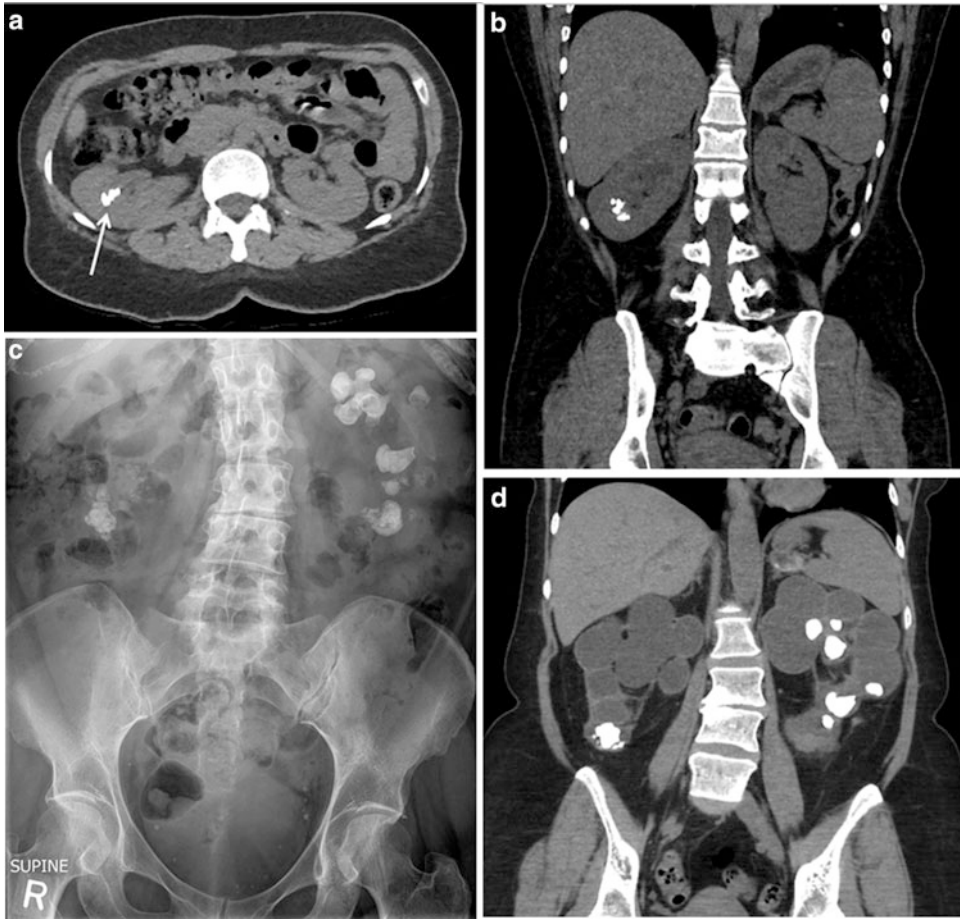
CT of renal calculi. (a) Axial unenhanced CT image shows multiple calcified stones in the right renal collecting system (*arrow*) with no stones in the left kidney. (b) The coronally reformatted CT image shows the stones in the right renal lower polar collecting system and right renal hydronephrosis. (c) Supine X-ray in a different
